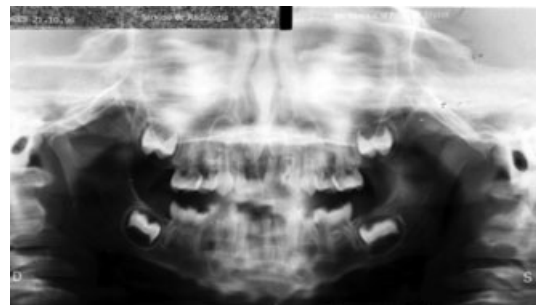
Panoramic radiograph at the age of 2 years 10 months. Presence of a calcified tissue mass in the traumatized area.
